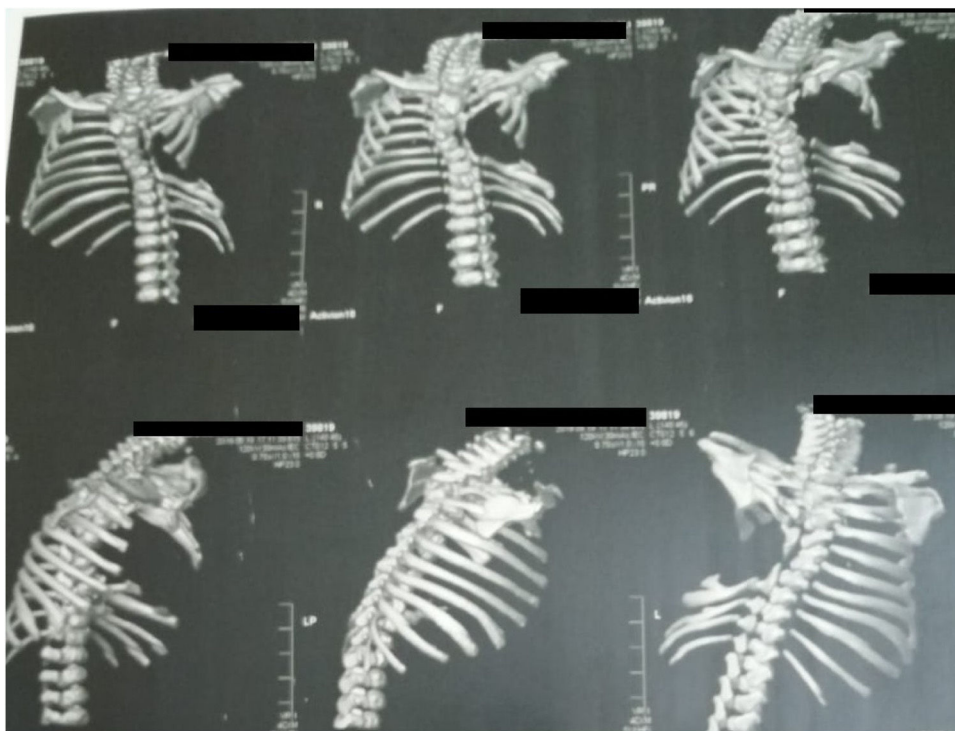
CT chest with 3D reconstruction showing complete absence of left 5th–8th ribs while the rest of ribs are normal.
